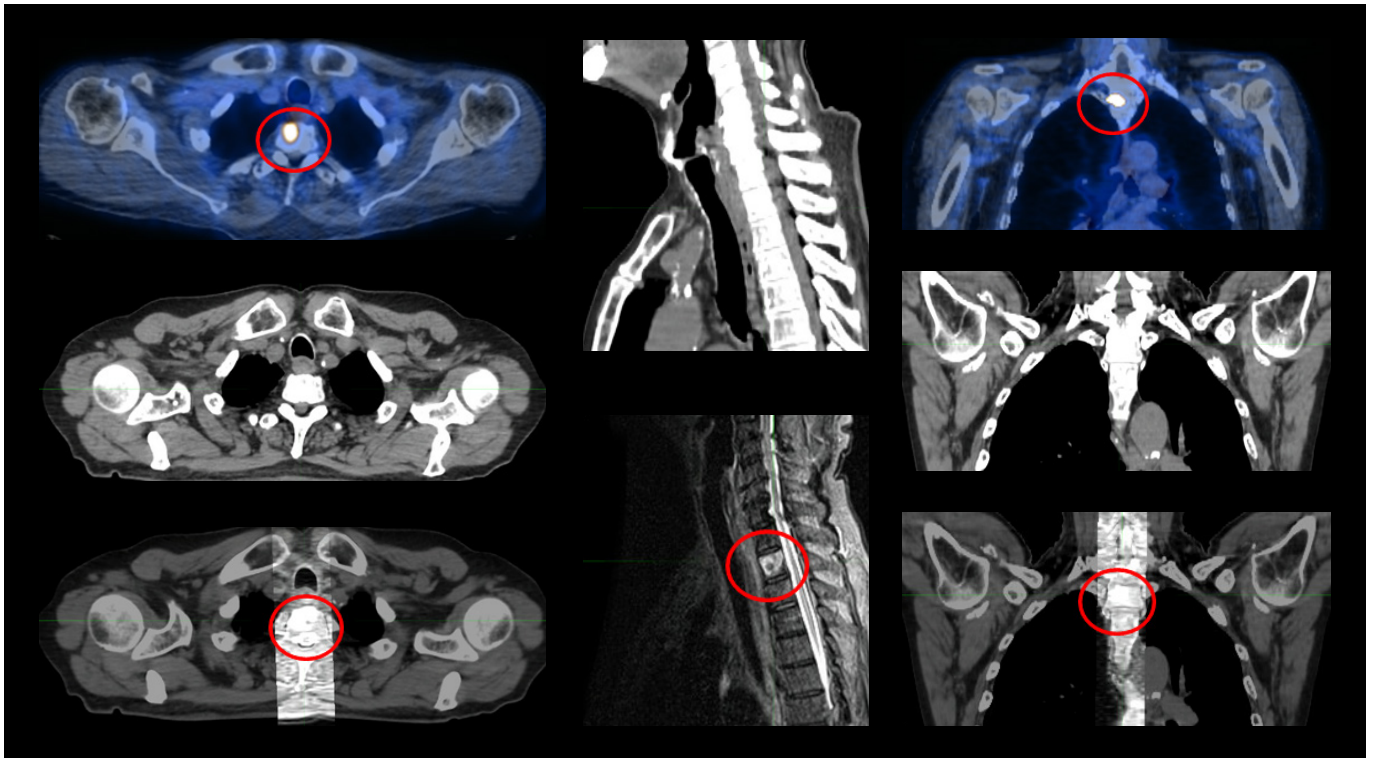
PET, CT, and fusion of SAG STIR MR with CT images are shown from the top to the bottom row. The target is shown within the red circle. CT is unable to identify the lesion.
